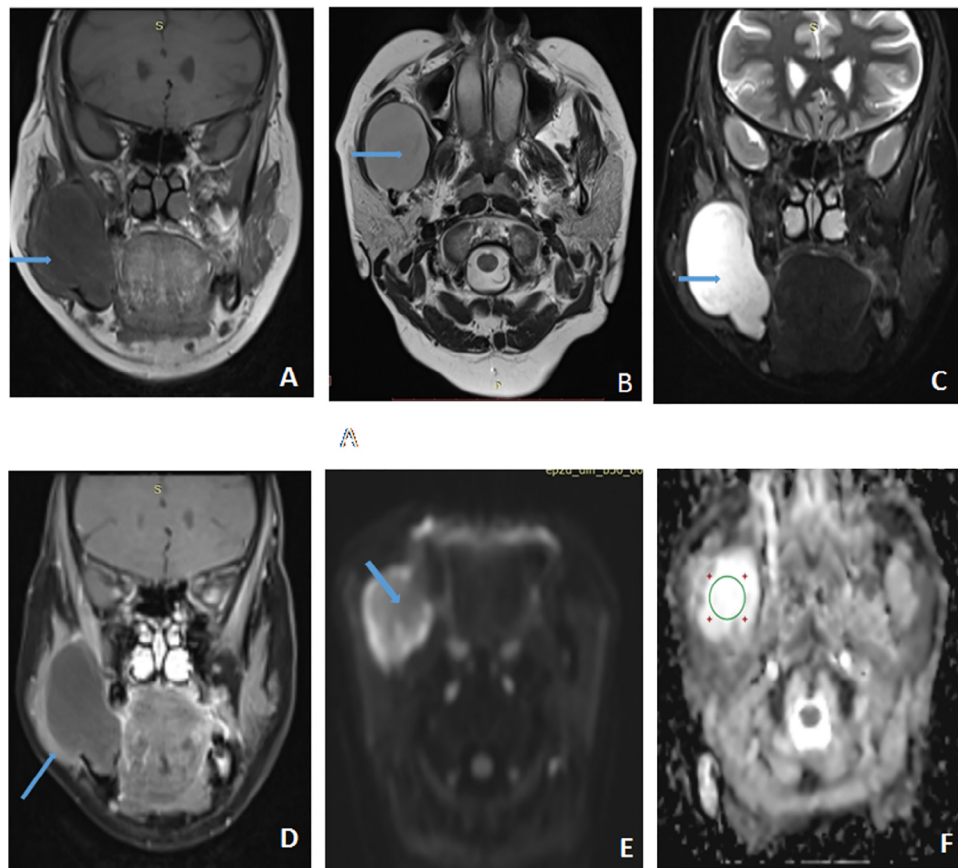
A–F, A 48-year-old female patient with unicystic ameloblastoma (UAB). Coronal T1-weighted image (A) shows a well-defined hypointense lesion (blue arrow) in the body and ramus of the mandible on the right side. Axial T2 and coronal STIR images (B, C) show the lesion (blue arrow) with high signal intensity. Coronal T1-weighted image (D) shows thin peripheral rim enhancement (blue arrow). Axial diffusion-weighted imaging (DWI) scan (E) shows a hypointense signal (blue arrow) with hyperintensity on the corresponding apparent diffusion coefficient (ADC) map (F) suggestive of facilitated diffusion (green circle). Mean ADC value of the lesion is $2.315 \times 10^{-3} \text{ mm}^2/\text{s}$.
